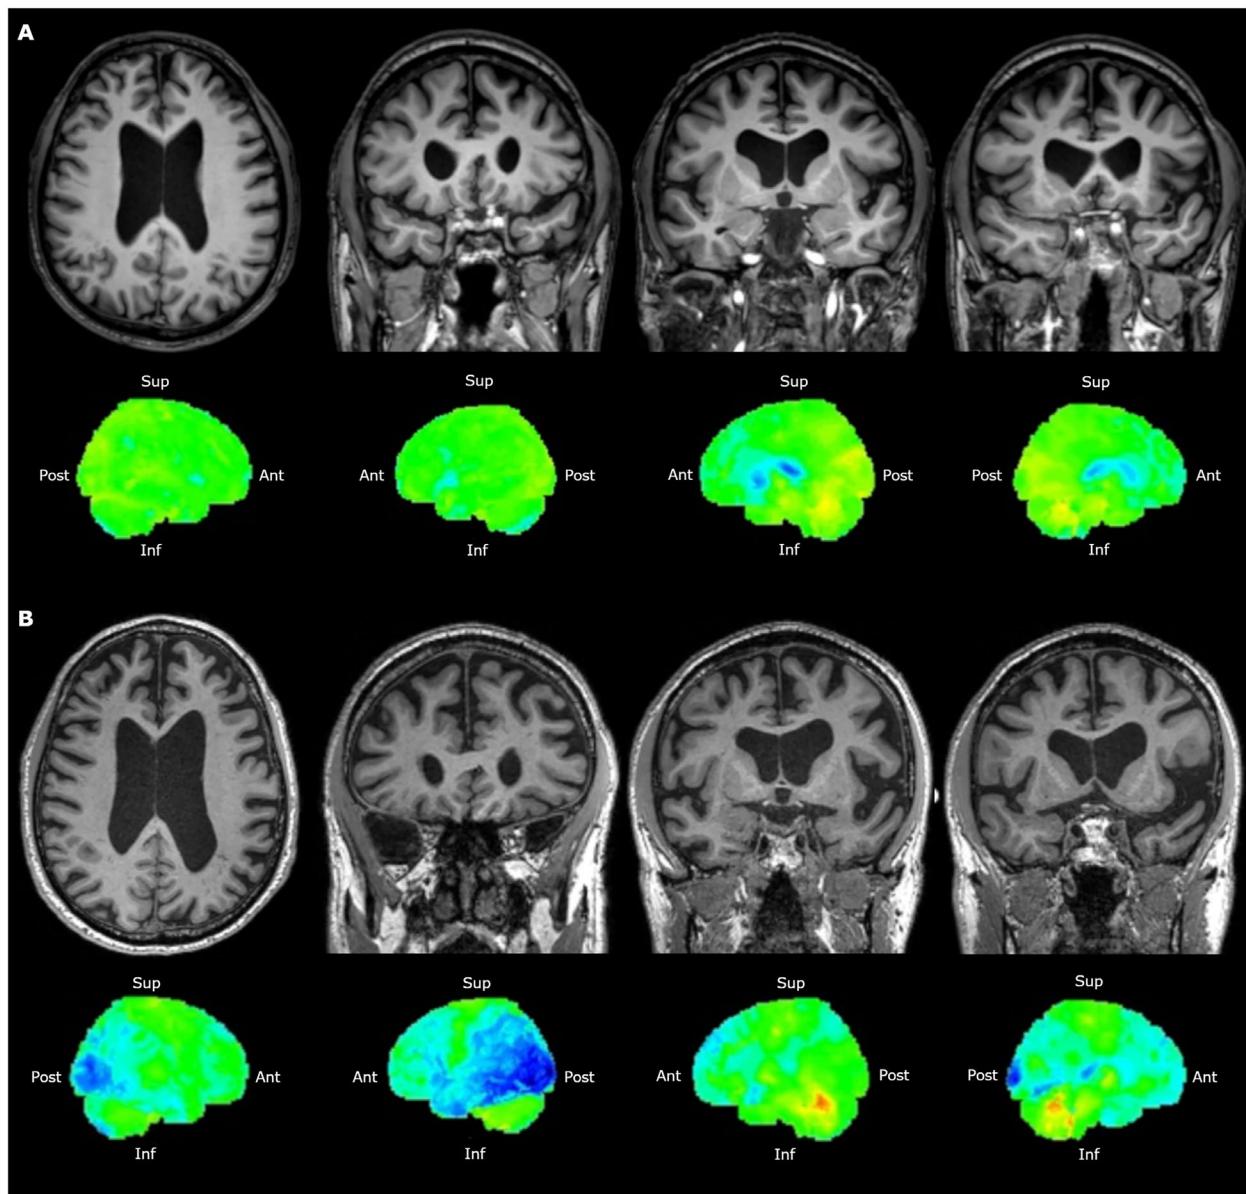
Neuroimaging findings. Neuroimaging findings in Cases 1 (Panel A) and 2 (Panel B). The upper row in each panel displays T1-weighted magnetic resonance imaging (MRI), left to right: axial, and coronal slices showing anterior cingulate and orbitofrontal, frontal insula, and anterior temporal regions [9]. All MRI images are in radiological orientation. The bottom row in each panel displays 3-dimensional stereotactic surface projection (3D-SSP) analyses of [¹⁸F]fluorodeoxyglucose positron emission tomography-computed tomography ([¹⁸F]FDG-PET/CT) images, left to right: right lateral, left lateral, right medial, and left medial. Orientation in the body is described as anterior (Ant), posterior (Post), superior (Sup), and inferior (Inf). The intensity normalization is based on the cerebellum as a reference region. Green colors indicate normal glucose metabolism, blue colors indicate hypometabolism, and orange-red colors indicate high metabolic activity. (A) Case 1 showed mild global atrophy and normal metabolism of the brain. (B) Case 2 exhibited prominent, left-lateralized, atrophy and hypometabolism of occipitoparietotemporal and frontal regions, with preservation of the posterior cingulate cortex.
